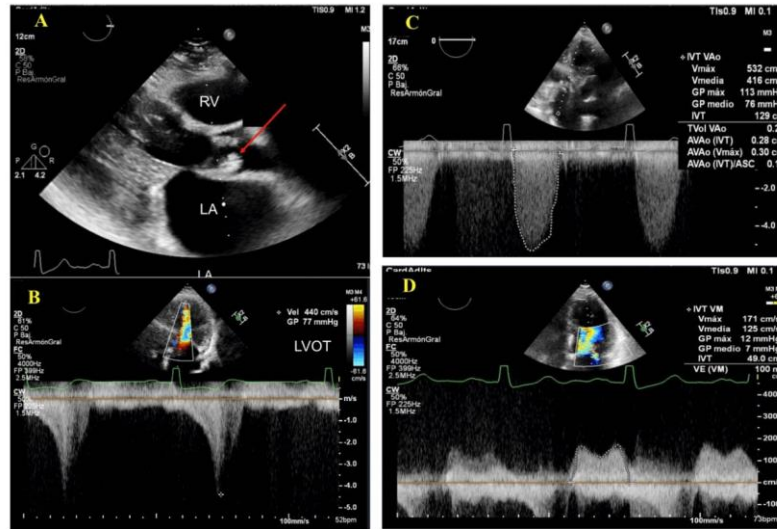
Transthoracic echocardiography. (A) Severe concentric left ventricular hypertrophy (LVH), indexed mass 222 g/m². (B) Resting LVOT gradient of 77 mmHg due to systolic anterior motion (SAM) of the mitral valve. (C) Severe aortic stenosis with moderate regurgitation. (D) Moderate mitral stenosis and regurgitation.
